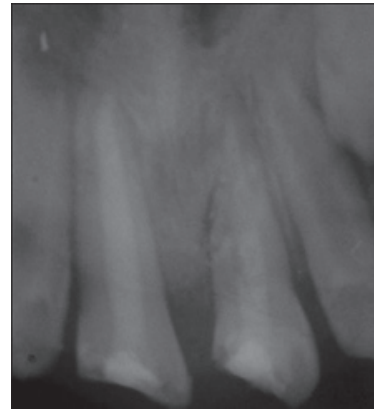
Periapical radiograph showing the apices formation.
